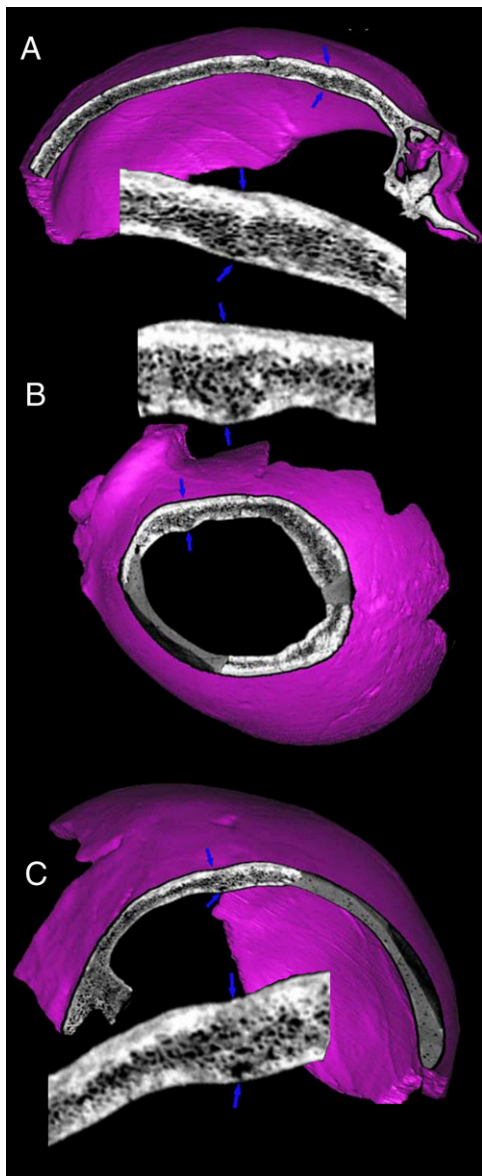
CT reconstructions and cross-sections in the area of the lateral frontal lesion. (A–C) Parasagittal view (A), superolateral view (B), and coronal view (C). Each view is oriented such that the external table of the lesion is above. The coronal view is looking posteriorly, such that the right side of the cranium is on the left.
